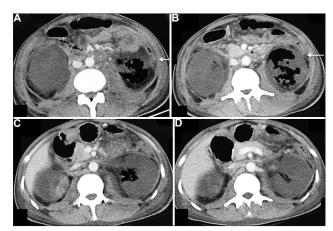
(A-D) Contrast-enhanced computed tomography abdomen Fig 2. (A-D) Intraoperative images during bilateral nephrectomy axial images showing bilateral non-enhancing globular enlarged showing dense adhesions around the kidney and thrombus visualized kidneys with perinephric inflammation and left emphysematous in the renal artery (arrow). pyelonephritis replacing the left kidney (arrow).
